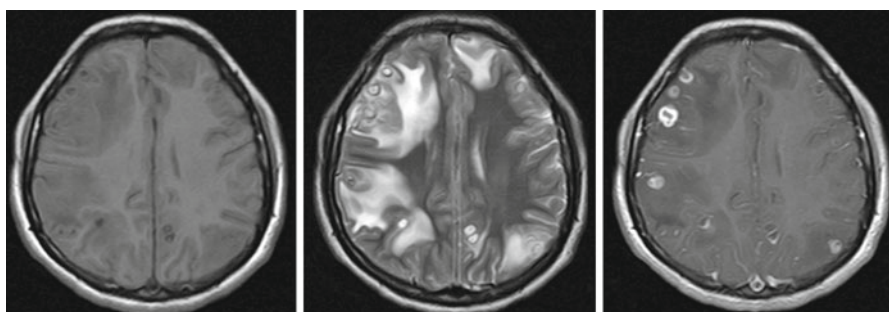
MRI of a patient with cysticercotic encephalitis. T1-weighted image showing diffuse brain edema and collapse of the ventricular system (*left*), T2-weighted imaging showing multiple colloidal cysticerci surrounded by edema (*center*) and contrast-enhanced imaging showing ring-enhancing lesions (*right*) (Reproduced with permission from: Del Brutto (2012b))
